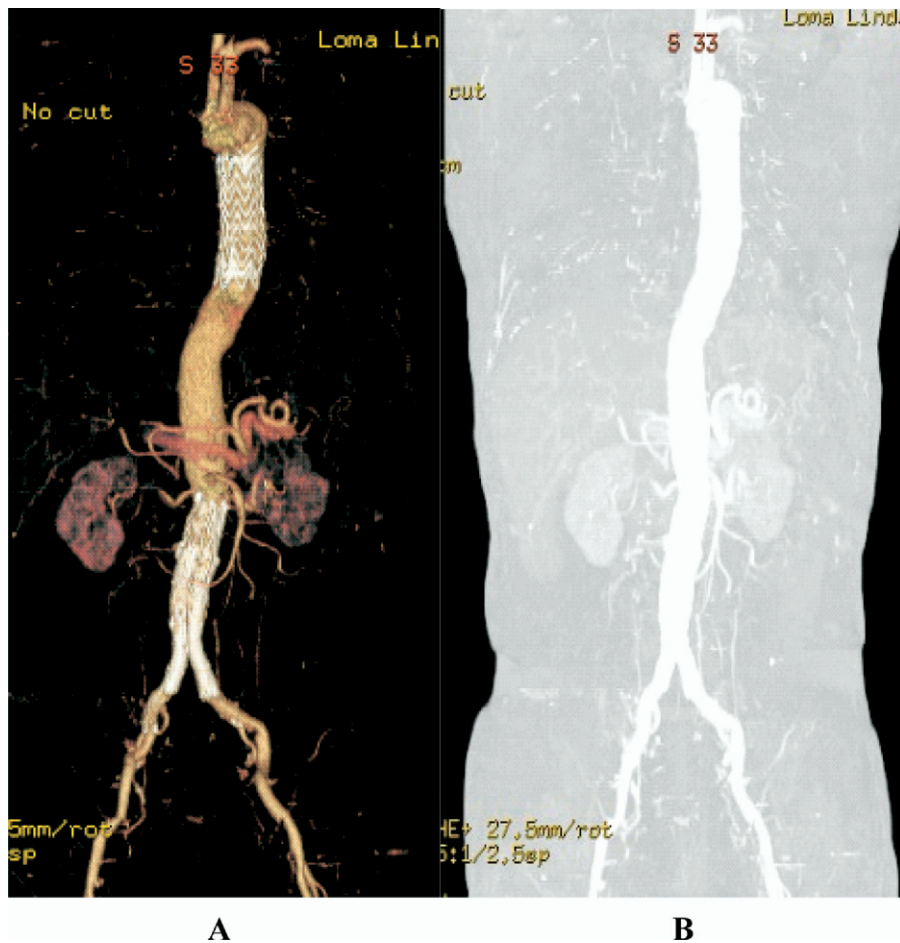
Follow-up CT scan with reconstruction demonstrated that the stent grafts were in good position (A); and thoracic and abdominal thrombi were completely excluded (B).
